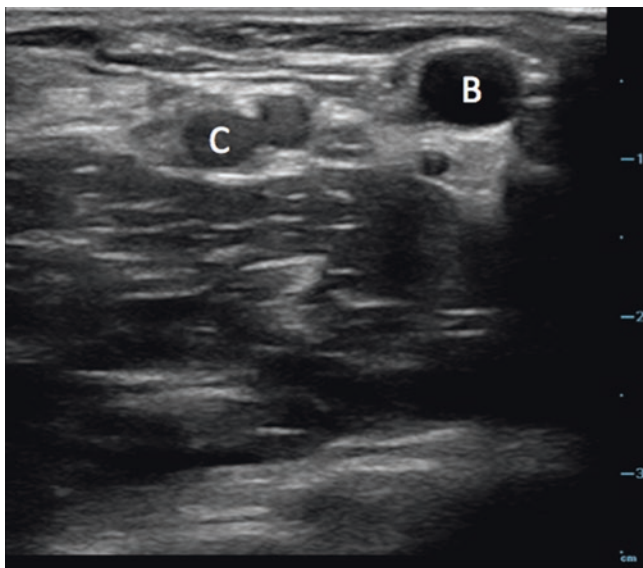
Ultrasound image of the right antecubital fossa. Circular blood vessel walls appear hyperechoic, while blood within the lumen appears anechoic. The basilic vein (B) can be visualized medially and the cephalic vein (C) laterally. Image courtesy of Stephen Alerhand
